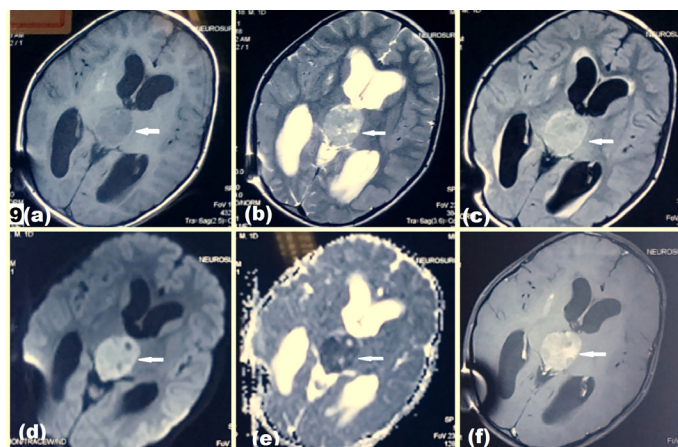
MRI of a 7-year-old boy with intraventricular germinoma (arrow) with evidence of mild hydrocephalus. (a) T1WI axial images showing an iso- to hypointense lesion in the posterior third ventricle. (b) On T2WI the lesion is heterogeneously hyperintense. (c) On FLAIR images the lesion is mildly hyperintense. (d-e) The lesion is showing high signal on diffusion image and low signal on ADC map, suggestive of diffusion restriction. (f) Post-gadolinium contrast, nearly homogenous enhancement is noted.
